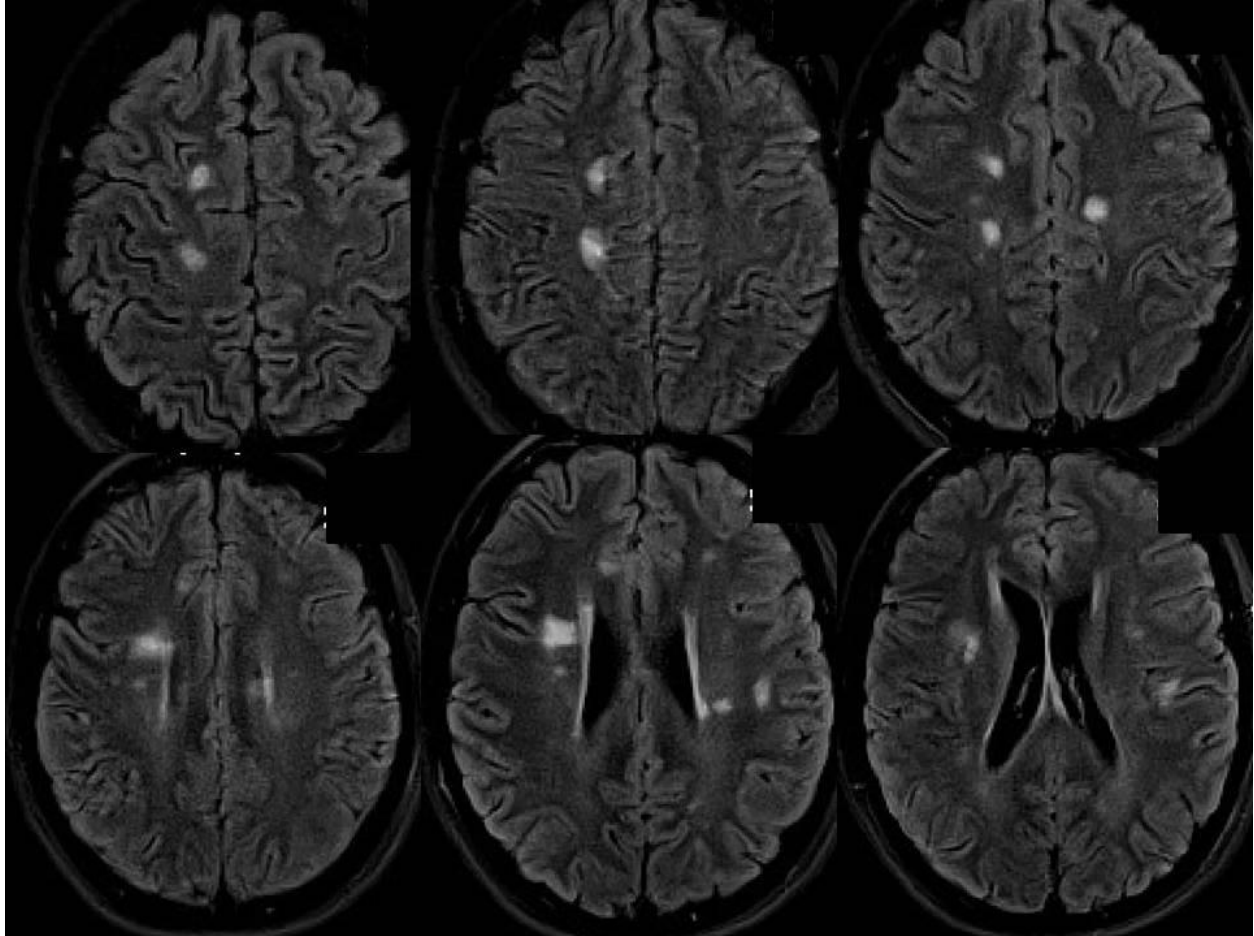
Axial brain images in a patient with the first episode of psychosis using magnetic resonance imaging.
